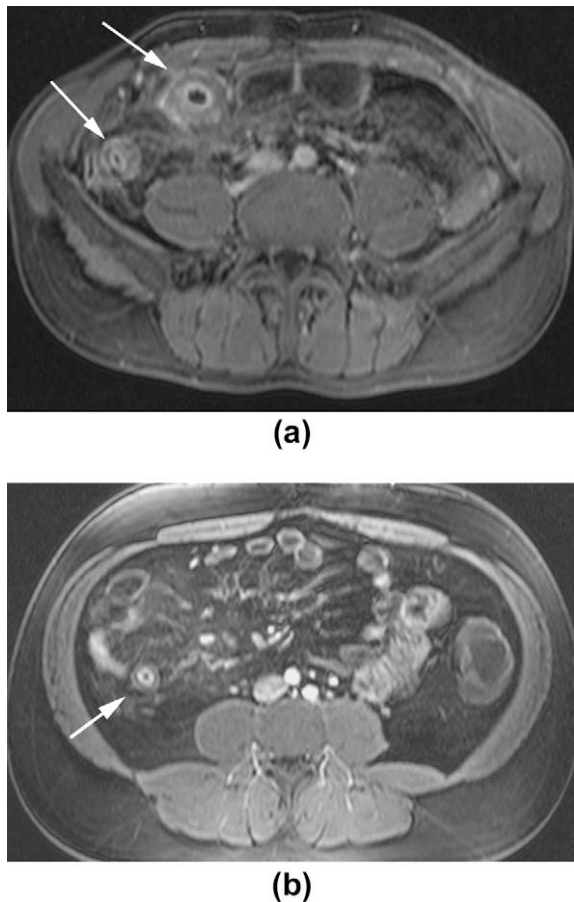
Contrast-enhanced, axial, T1-weighted, 3D source image obtained on an MREG examination with volumetric interpolated breath-hold examination (5.3/2.4/10°, 2.5 mm section thickness) shows the inflamed terminal ileum with layered enhancement (arrows) comprising of enhancing mucosa and serosa with the isointense, oedematous, submucosal layer in between (b) Axial, T1-weighted, 3D source image obtained with volumetric interpolated breath-hold examination (5.3/2.4/10°, 2.5 mm section thickness) shows the fat halo sign of chronic Crohn's disease manifesting as enhancing mucosa and serosa with a dark, hypointense submucosal layer.
